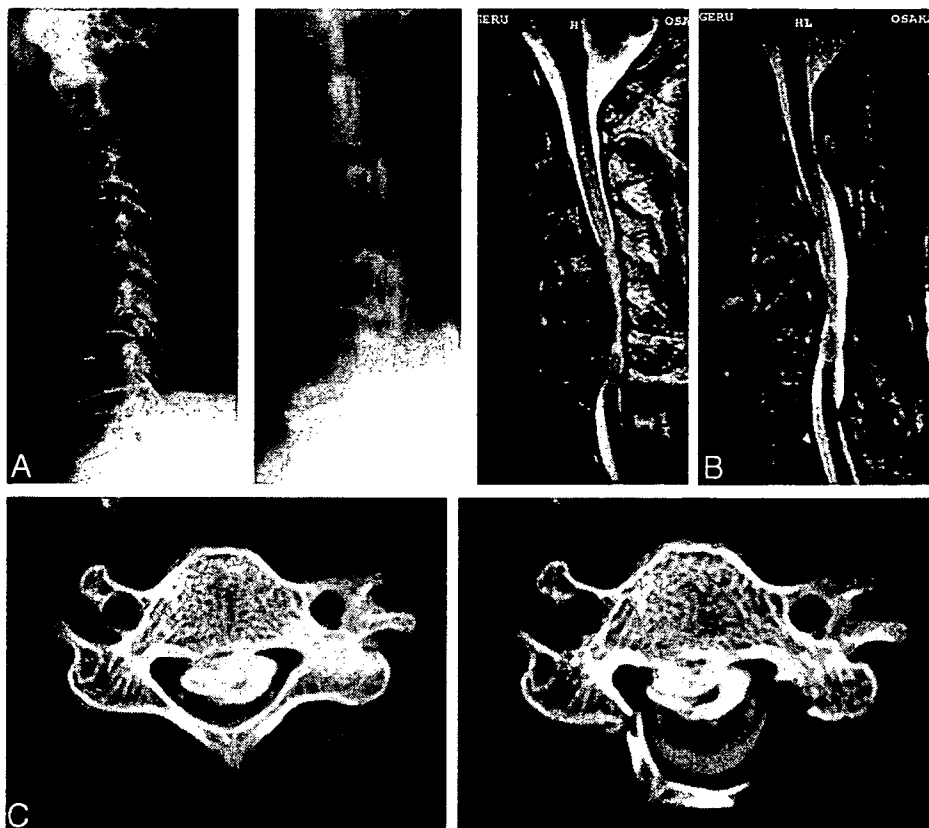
Case 8. A, Preoperative tomogram demonstrating hill-shaped ossification at C5–C6. B, T1-weighted MR image (left) and T2-weighted MR image (right) taken 5 years after laminoplasty demonstrating posterior decompression but remaining hill-shaped ossification in front of the spinal cord.
